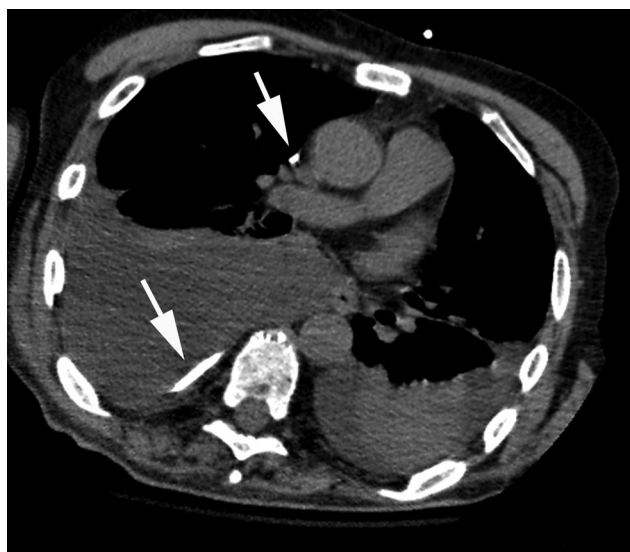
Computed tomogram showing predominant right pleural effusion with the ventriculopleural shunt catheter in the right hemithorax (arrows).
